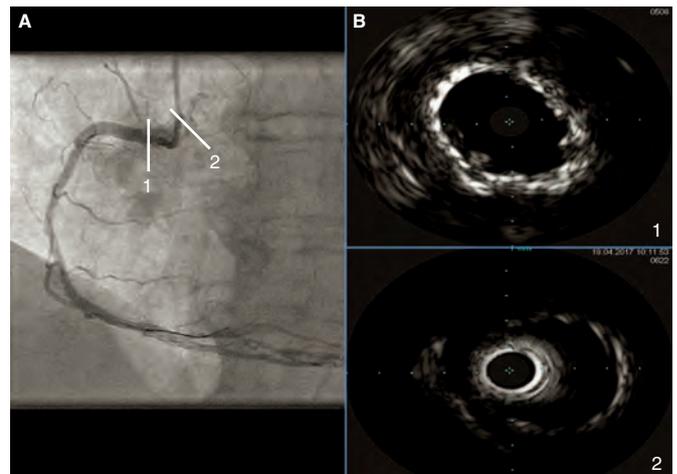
A: final angiographic result. B1: intracoronary ultrasound image showing the double layer of stents at ostium level with good stent apposition and expansion. B2: intracoronary ultrasound image showing the stent implanted in the first place, protruding into the aorta, and showing wide overexpansion.
